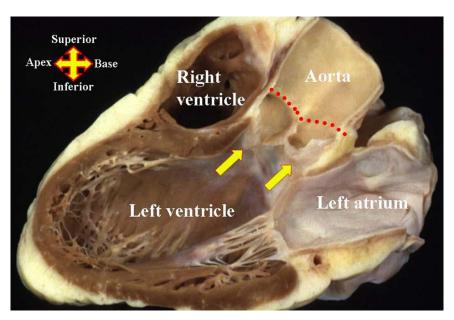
This section through the heart, replicating the parasternal long axis echocardiography cut, shows how the aortic root is the centerpiece of the heart. The root extends from the basal attachments of the valvar leaflets within the ventricle (yellow arrows) to the sinutubular junction (red dotted line). The compass shows the orientation relative to the remaining thoracic organs. (Antunes, 2005)
